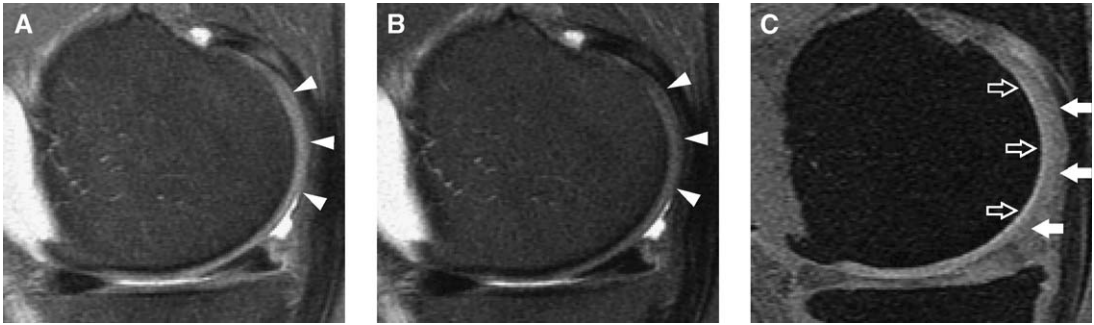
Ambiguity of cartilage surface contour on three-dimensional SPGR image. MR images in a 60-year-old man. Sagittal short TE FSE image (4000/13) (A) and long TE FSE image (4000/39) with fat suppression (B) showing clearly defined cartilage contour (arrowheads) in the region of the posterior femoral condyle. (C) Sagittal fat-suppressed three-dimensional SPGR image (60/5, 40°-flip angle) shows ambiguous surface contour (arrows) on the posterior region of the femoral condyle cartilage. (From Yoshioka H, Stevens K, Genovese M, et al. Articular cartilage of knee: normal patterns at MR imaging that mimic disease in healthy subjects and patients with osteoarthritis. *Radiology* 2004;231:31–8; with permission.)
